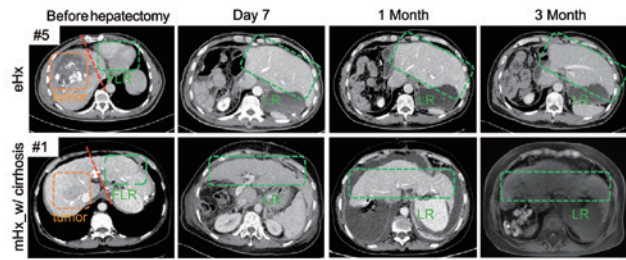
Assessment of liver regeneration in patients with extended liver resection by CT volumetry. The yellow box represents the tumor, and the green boxes represent the future liver remnant or liver remnant²⁴.
